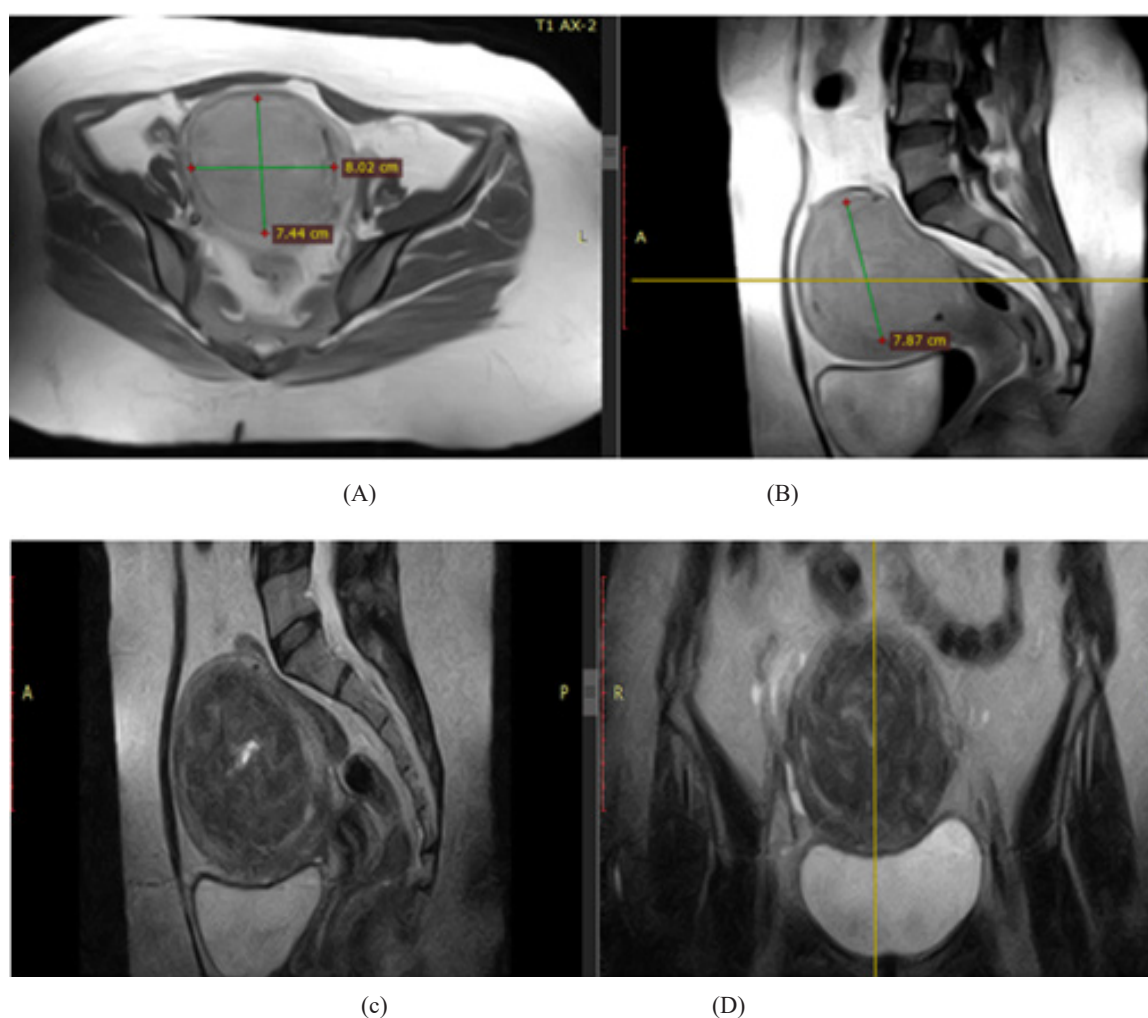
A 41-year-old female presented with frequent painful heavy menstruation and dyspareunia, she underwent one MR-HIFU session, and now the patient has a tolerable menstrual cycle with an average amount and the dyspareunia was remarkably relieved. T1 axial (A), T1 sagittal (B), T2 sagittal (C) and T2 coronal (D) MRI images demonstrate anterior wall interstitial myoma, showing intermediate/high signal denoting FUNAKI-type III with internal areas of cystic degeneration and iso-intense signal in T1 WIs with peripheral rim of low signal. Total myoma volume before HIFU = 234 cc
